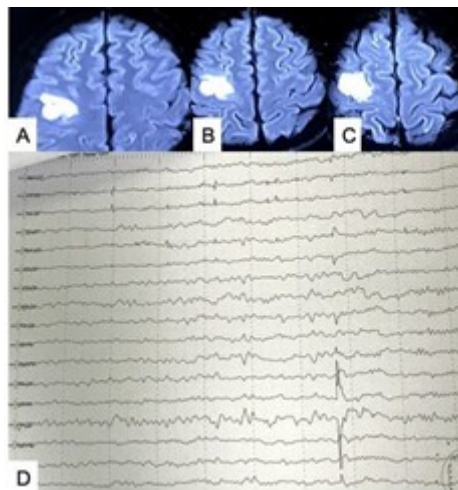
(A–C) MRI of brain axial sections showing right middle frontal gyrus FCD. (D) EEG showing right frontal focal discharge. Source: Figure by authors.
